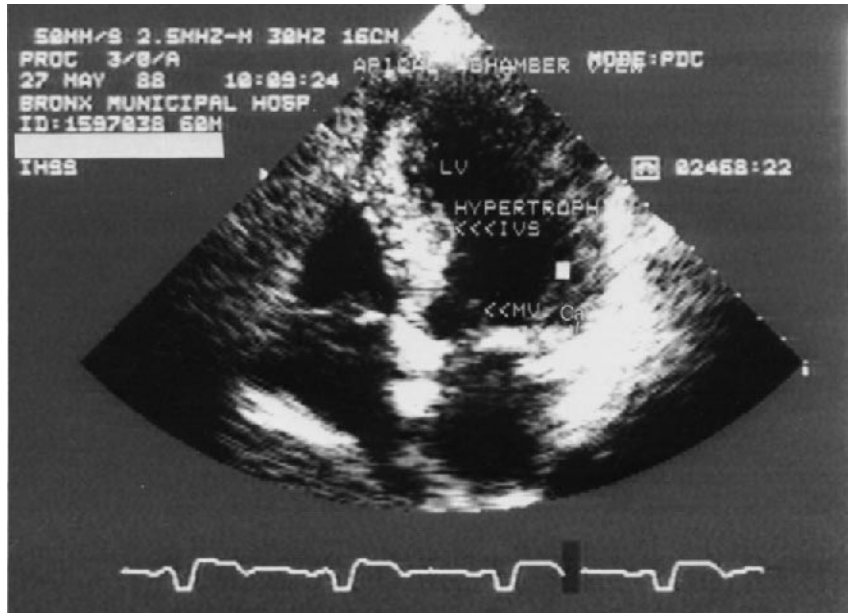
Two-dimensional apical four-chamber systolic still frame from an elderly patient with obstructive hypertrophic cardiomyopathy shows hypertrophy of the interventricular septum (IVS), a small LV cavity, fibrotic mitral valve (MV) leaflets, and a calcified mitral annulus (Ca).
